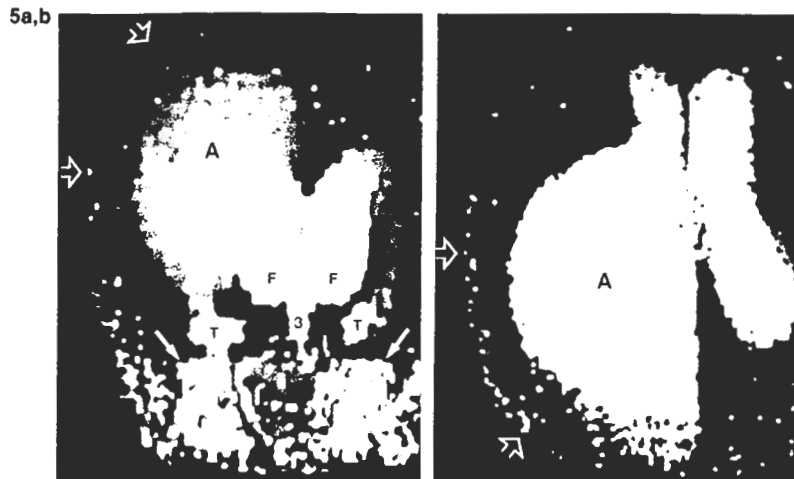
3D noncontrast CT scans show asymmetric atrial dilatation with calvarial expansion in a 23-month-old boy. Frontal (a) and superior (b) views document that the asymmetric expansion (open arrows) of the hemicalvarium results from relatively focal ballooning of the atrium (A) with little, if any, midline shift. Frontal horns (F), temporal horns (T), and third ventricle (3) are slightly dilated. The globes (solid arrows) appear in proper position in the images.
